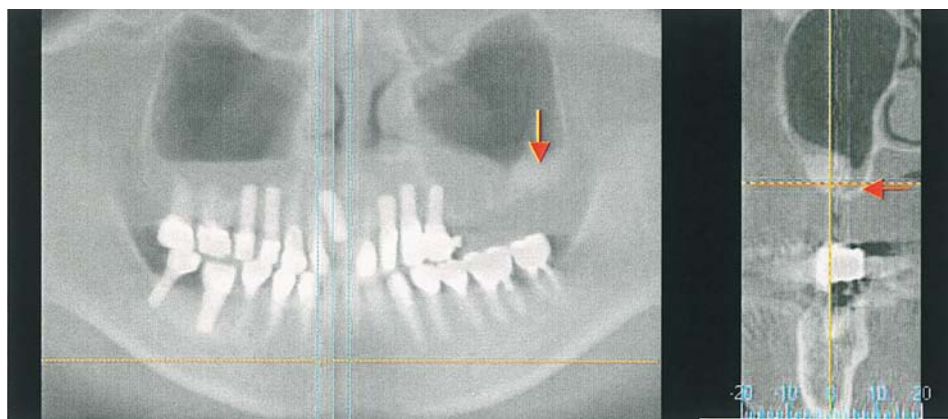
Panoramic and CT images of grafting site after surgery. Grafting material was not fill by medial wall. Red arrows show the grafting site.
